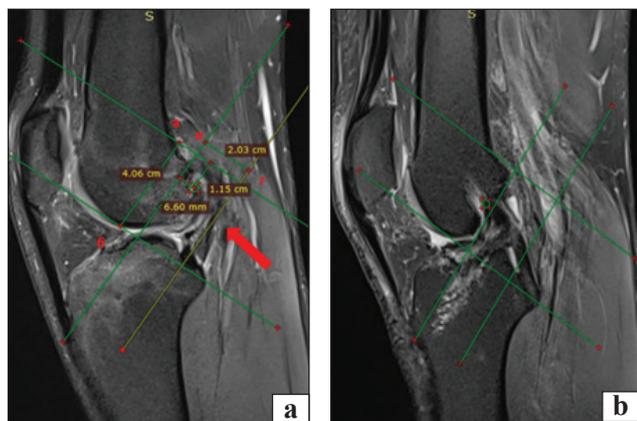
MRI, sagittal projection. Line a–b is the posterior-anterior direction, line c–d is the superior-inferior. The arrow indicates the circle, the point of entry of the femoral canal. In the image, the point of entry is located in the posterior-anterior direction and 33% in the superior-inferior direction (a); the point of entry of the femoral canal is outside the Bernhard and Hertel rectangle (b)
